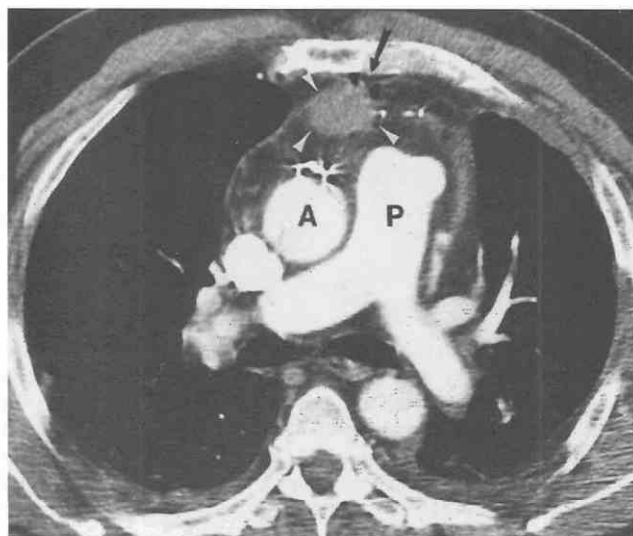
Mediastinitis manifesting as mediastinal abscess. CT shows a poorly margined heterogeneous soft tissue mass (arrowheads) in the anterior mediastinum. Note the absence of air within the abscess. The needle was positive for *Staphylococcus aureus* infection. B, brachiocephalic artery; S, superior vena cava.
